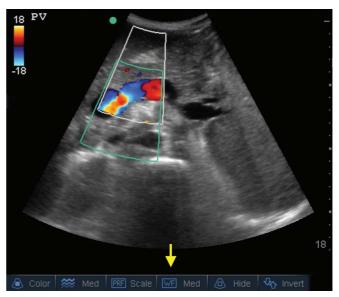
Portal vein with optimized wall filter. The wall filter (WF; arrow) is set at medium. In some point-of-care ultrasound machines, the wall filter setting may be directly linked to the scale or pulse repetition frequency setting.
